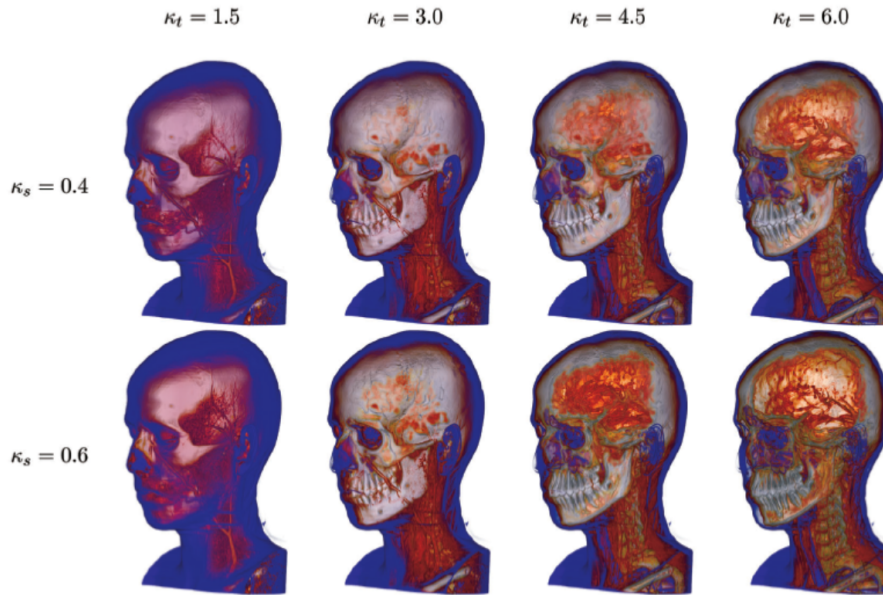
Context-preserving volume rendering of a contrast-enhanced CT angiography dataset using different values of the two parameters. Columns have the same κ_t value and rows have the same κ_s value. Image courtesy of Bruckner *et al.* [22].
